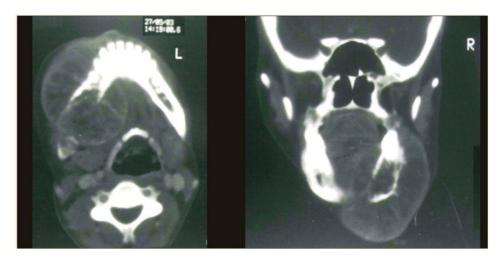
CT scan (Bone window images) of axial and coronal section of mandible
